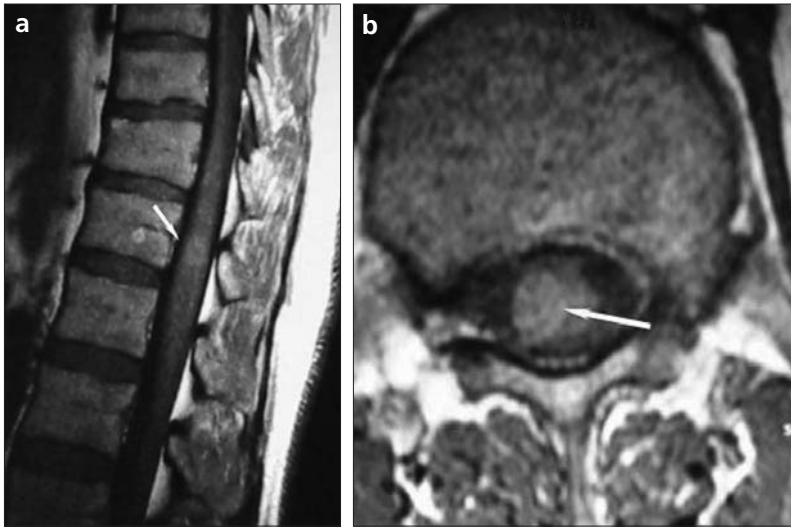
a, b. Sagittal (a) and axial (b) T1-weighted MR images show nodular, slightly hyperintense intramedullary lesion (arrow) at the T12 level.
